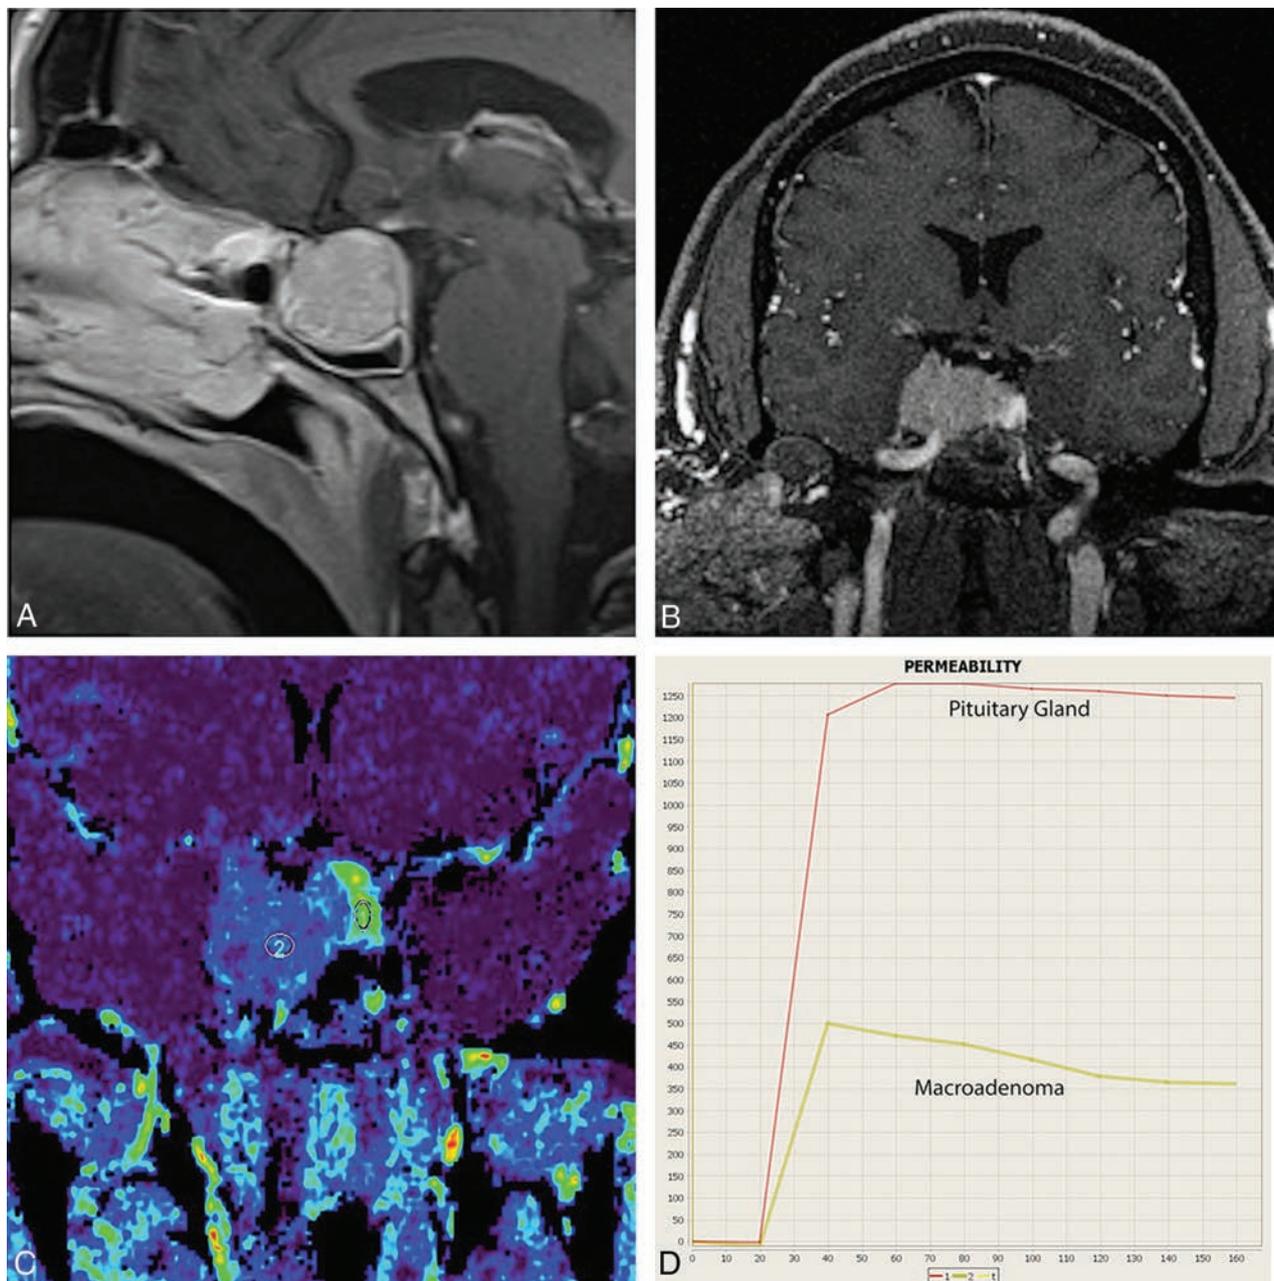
A, Contrast-enhanced sagittal T1WI demonstrates a macroadenoma. B, GRASP dynamic MR imaging through the sella demonstrates the macroadenoma extending into the right cavernous sinus. A focal area of increased enhancement is seen along the left lateral aspect of the lesions. C, Postprocessed MR permeability peak scan demonstrates a focal area of increased contrast uptake (ROI 1) from the left lateral aspect of the sella compared with the macroadenoma (ROI 2). D, The enhancement-time curve confirms that the normal pituitary gland, localized along the left lateral aspect of the sella, enhances earlier and more robustly than the macroadenoma.
